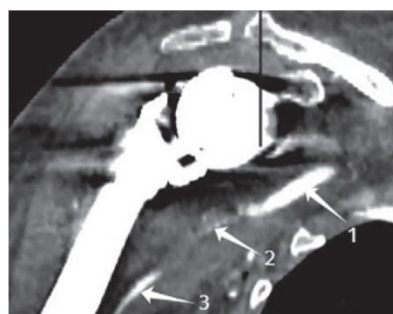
CT-angiogram of the right upper limb: 1 — axillary artery, 2 — synthetic prosthesis, 3 — brachial artery
